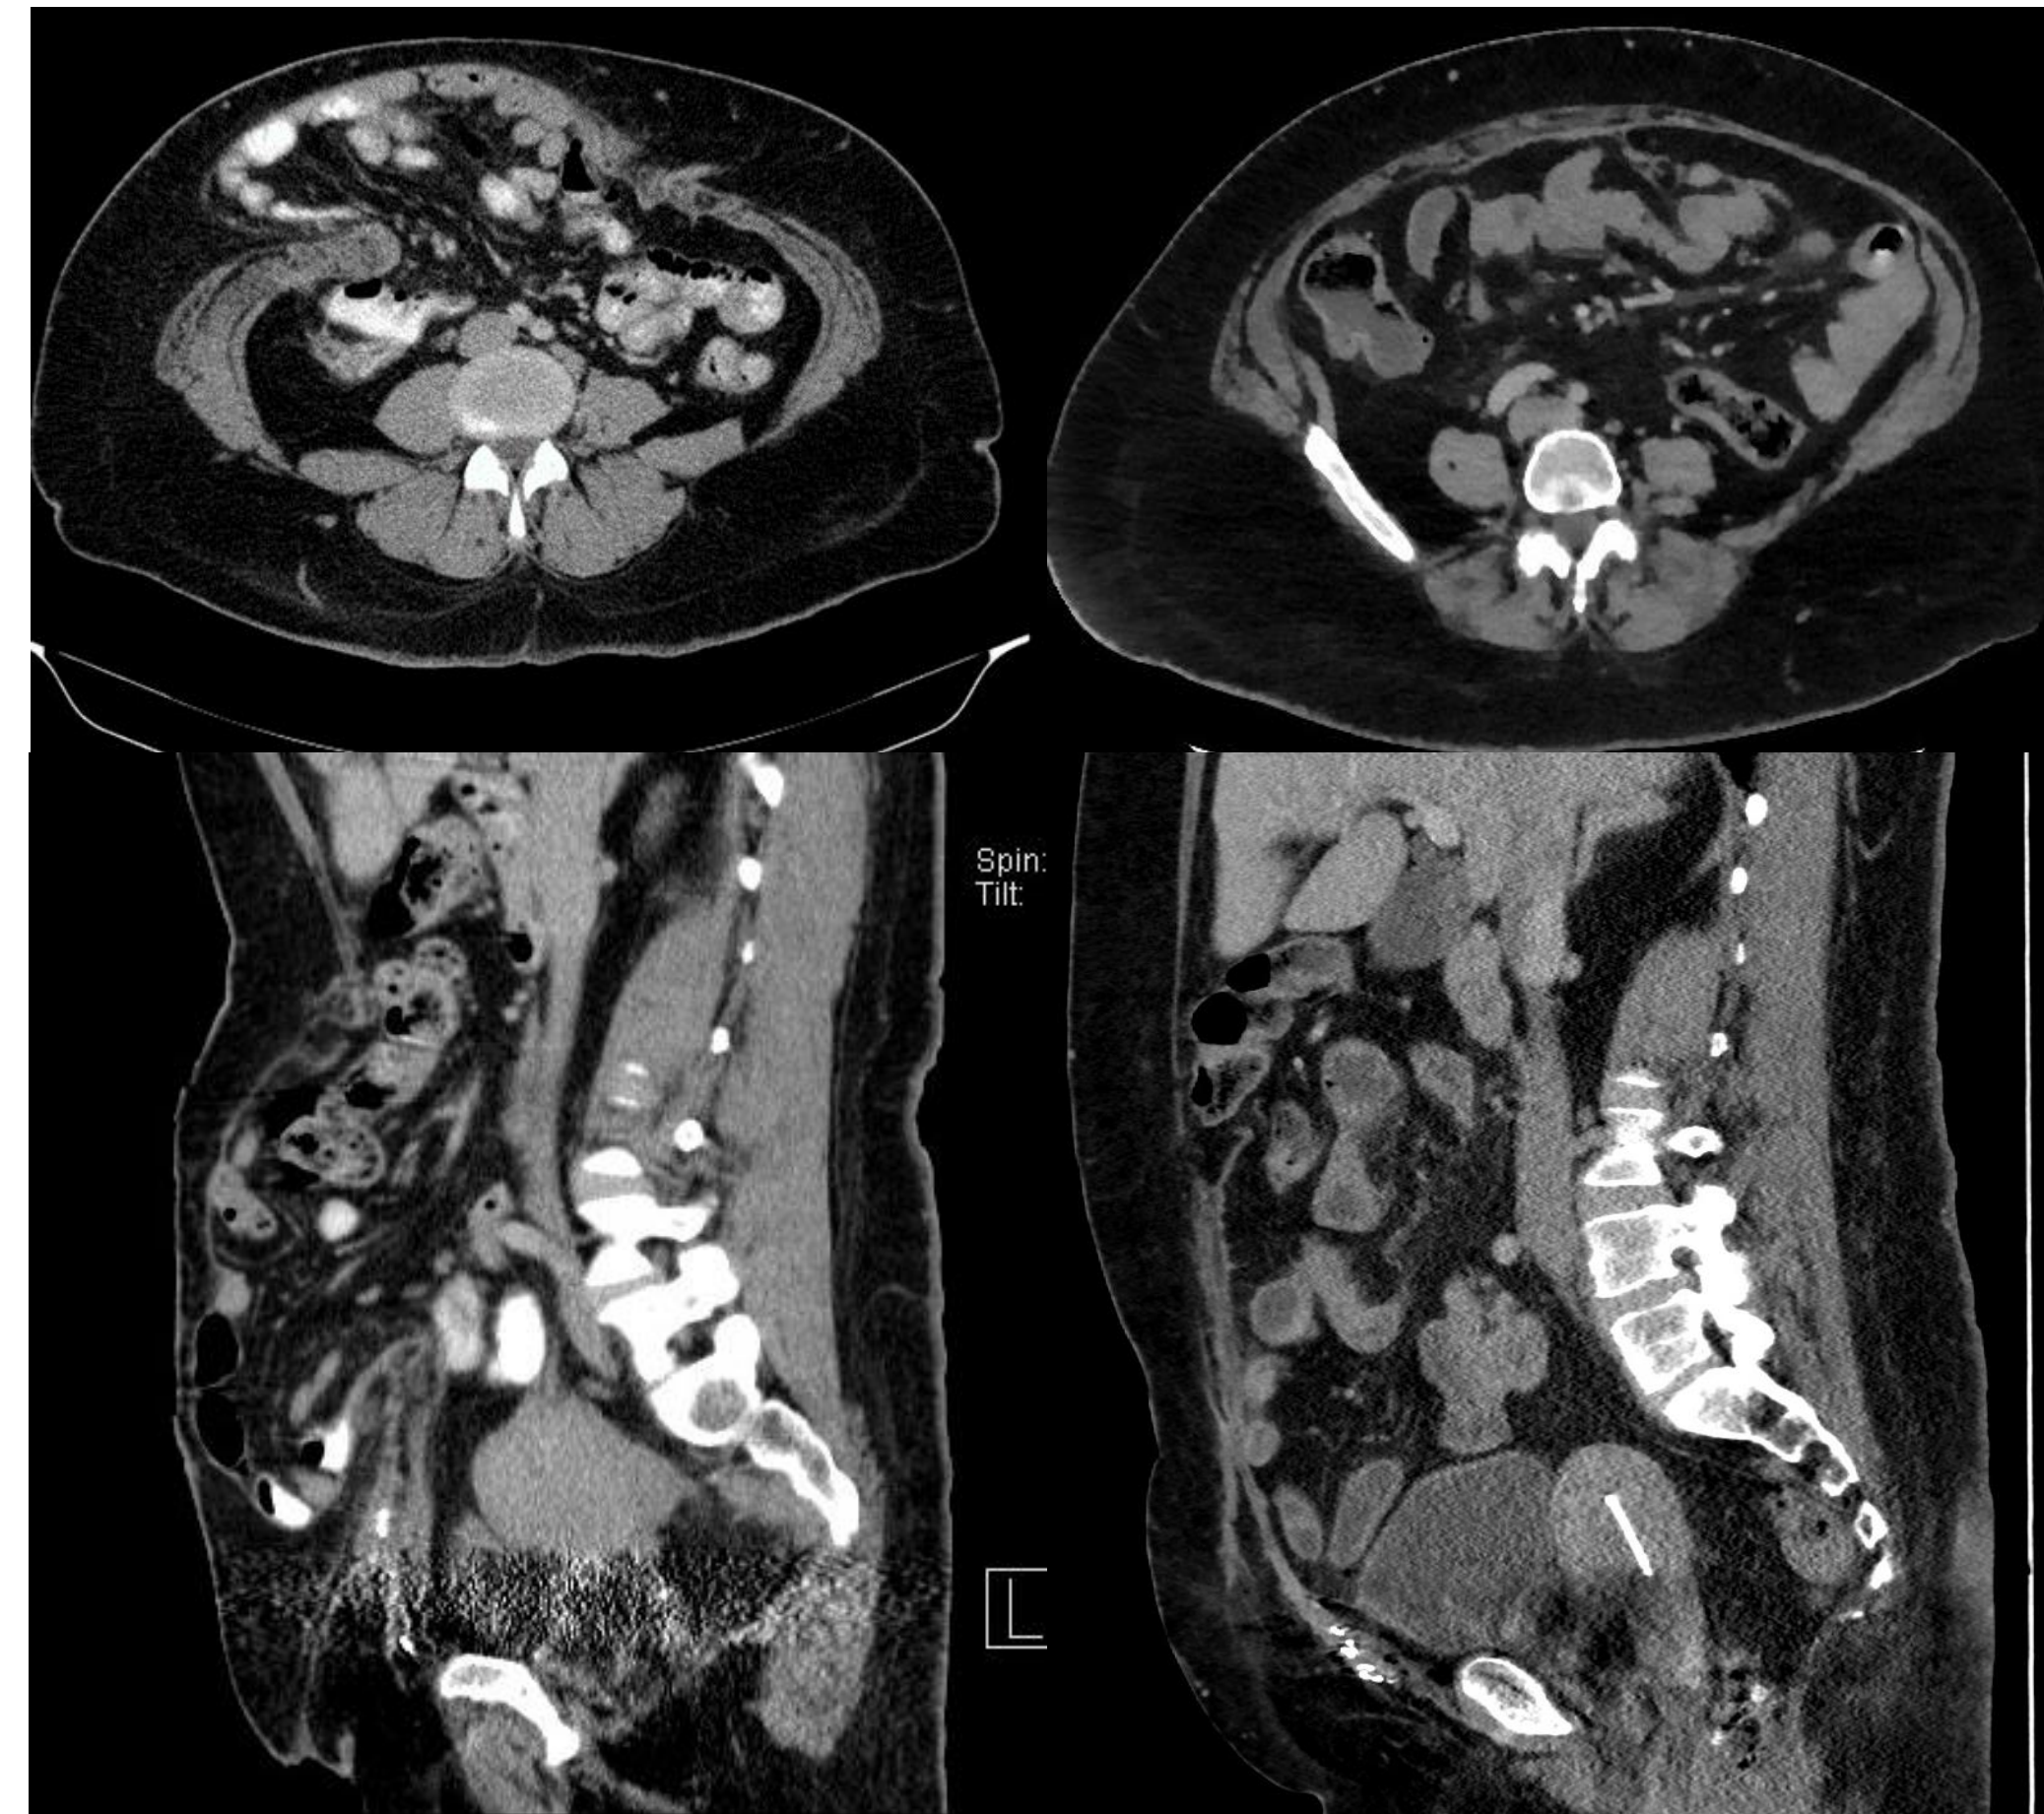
49 year old woman with a recurrent incisional hernia following laparoscopic repair of an incisional hernia after an open anterior resection. *Top left:* preoperative axial computed topography (CT) image showing a large ventral hernia containing small bowel with a large hernia neck. *Bottom left:* Sagittal CT image showing her hernia containing small and large bowel. *Top right:* Axial CT image performed 4 years post elective TAR with good results. *Bottom right:* Sagittal CT image showing a successful repair.
